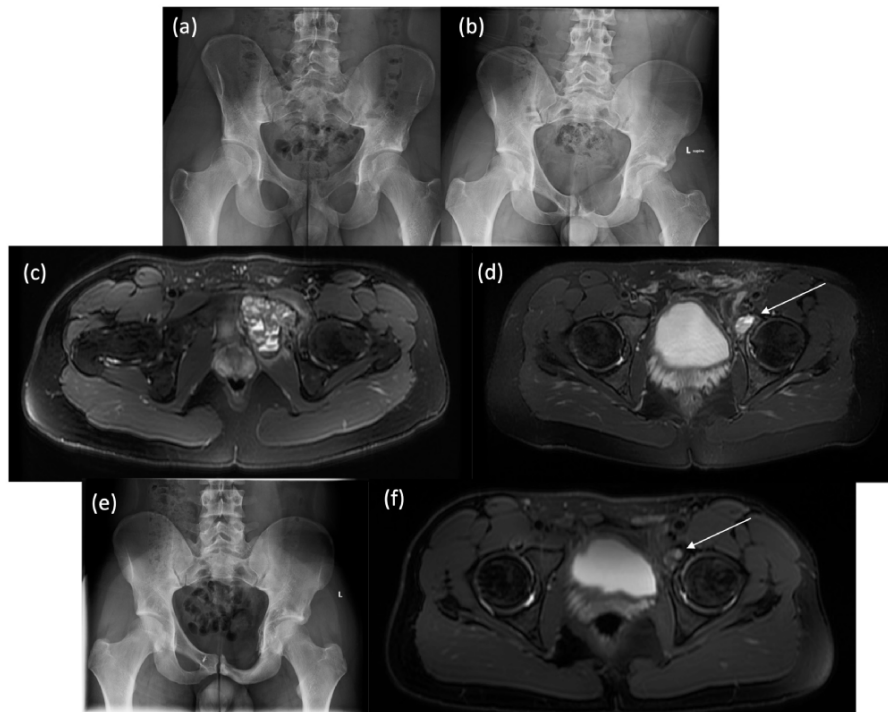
Preoperative and postoperative imaging of Patient 4's left hip. (a) Preoperative standing AP pelvic radiograph demonstrating a lytic lesion in the left superior pubic ramus. (b) Repeat preoperative standing AP radiograph of the pelvis obtained 2 months later demonstrating interval progression with further extension into the pubic body and cortical thinning. (c) Preoperative axial T2-weighted MR image showing an expansile lesion with multiple fluid-fluid levels characteristic of an ABC. (d) Postoperative axial T2-weighted MRI at the 4-month interval demonstrating a small T2 hyperintense lesion with fluid-fluid levels centered at the superior pubic root (arrow) consistent with a recurrence. (e) Postoperative and post sclerotherapy AP pelvis radiograph at the 4-year postoperative interval showing no further evidence of recurrence and preserved joint spaces. (f) Postoperative and post sclerotherapy post contrast axial T1-weighted image showing resolution of recurrence and filling of the lesion (arrow).
